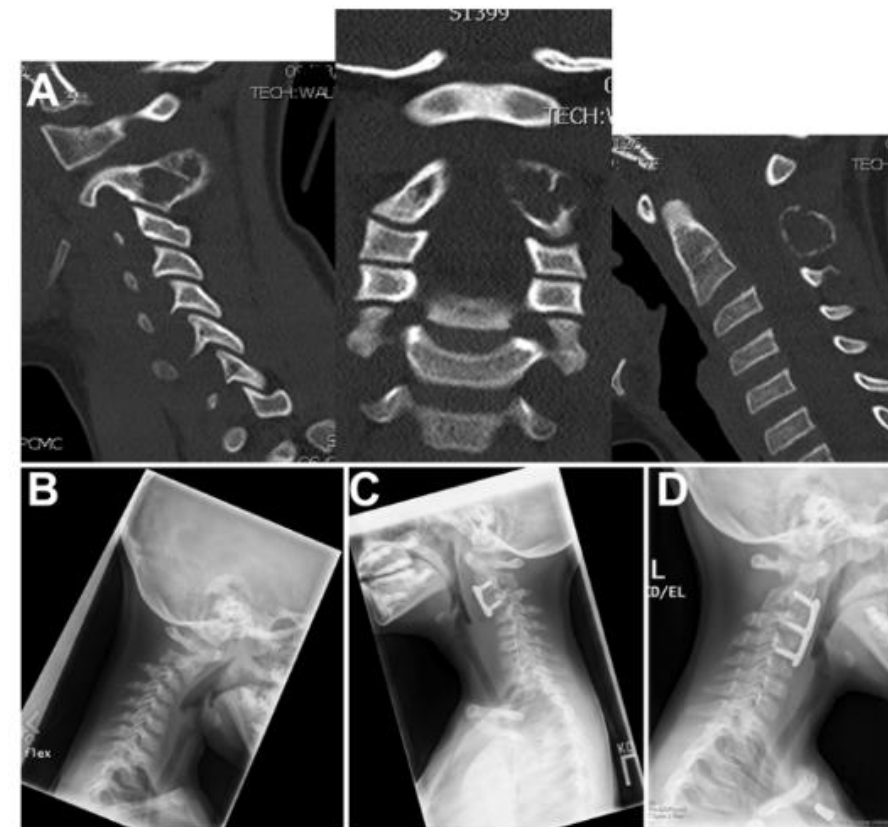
Case 2. A: Sagittal (left), coronal (center), and midsagittal (right) noncontrast CT scans of the cervical spine showing an aneurysmal bone cyst involving the posterior elements of C-2. B: Lateral radiograph of the cervical spine after resection of the cyst showing kyphosis of C-2 on C-3. C: Lateral radiograph of the cervical spine after C2-3 ACDF showing appropriate hardware position but kyphosis at C3-4. D: Lateral radiograph of the cervical spine after C3-4 ACDF and removal of the C2-3 and C2-4 plates. The hardware is in good position and anatomical alignment is maintained.
